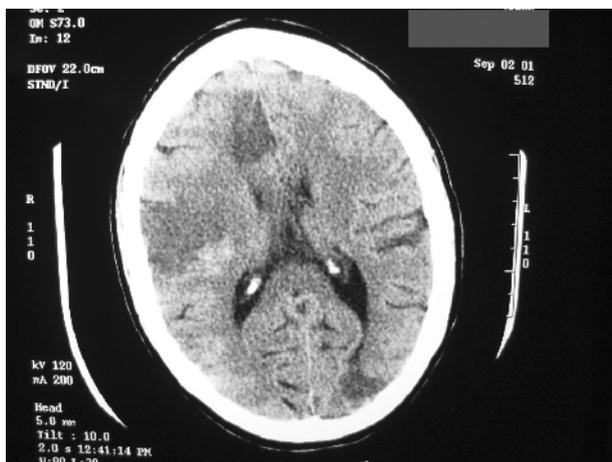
CT head: large acute infarct with petechial haemorrhage involving the right anterior and right middle cerebral artery territories
